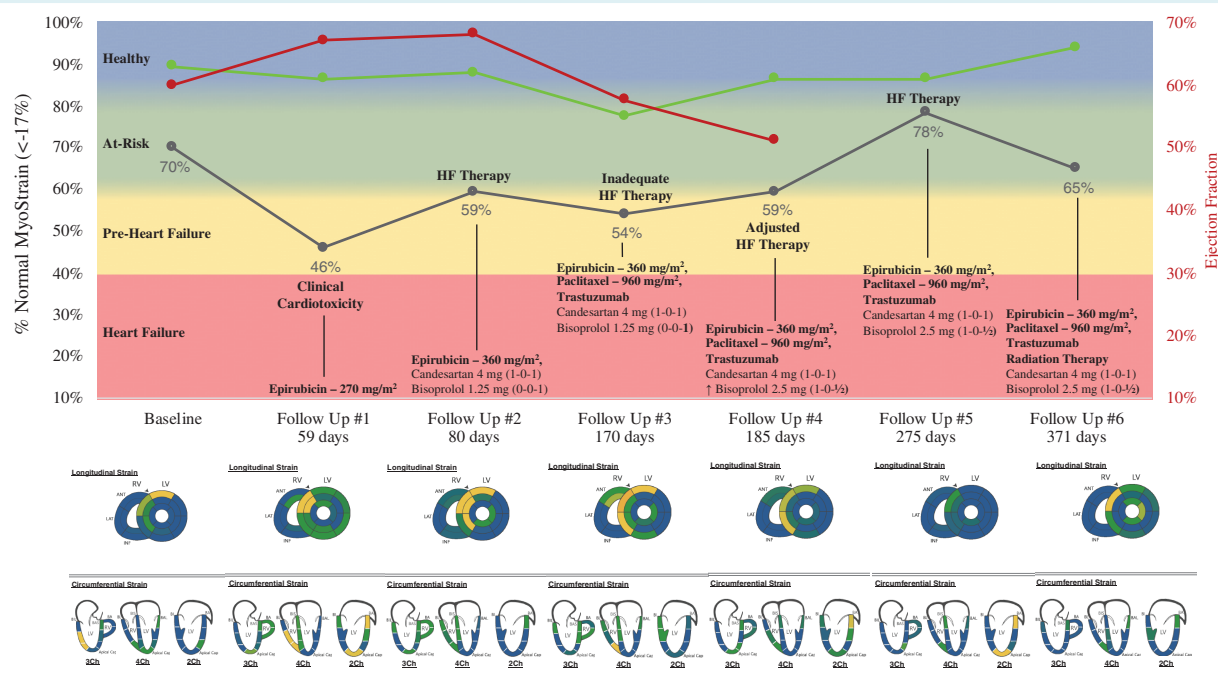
The case of a 52-year-old female suffering from HER2+ right breast cancer with a high risk of cardiotoxicity. Cardiac magnetic resonance (CMR) exams including Fast-SENC MyoStrain testing were performed at baseline and six follow-up intervals through 371 days after initiation of chemotherapy. The graph shows % normal MyoStrain ($\leq -17\%$) in black with cardiac magnetic resonance left ventricular ejection fraction in green and echocardiography left ventricular ejection fraction in red. Upon administration of 270 mg/m^2 epirubicin at 59 days of follow-up, the patient exhibited clinical cardiotoxicity, with MyoStrain % normal left ventricular myocardium worsened from 70% to 46%. Echocardiography left ventricular ejection fraction (60% to 67%) and global longitudinal strain (-19.7%) did not identify the cardiotoxic response. The dynamics of imaging parameters in response of titration of cardioprotective therapy is shown. MyoStrain segmental reports are shown below the graph of % normal MyoStrain (blue colour codes normal deformation, green codes strain in the range between -17% and -10% , yellow codes strain less than -10%).
